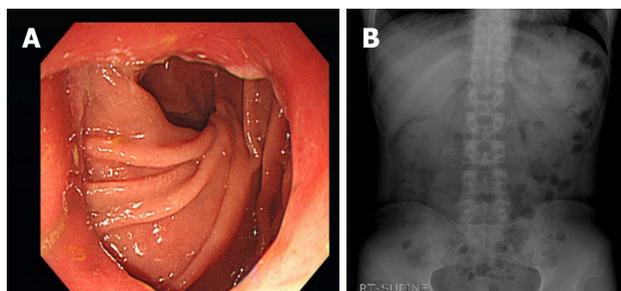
Patent anastomotic site on follow-up gastroscopy. A: Anastomotic lumen is patent; B: The stent is not identified on a follow-up abdominal radiograph.
